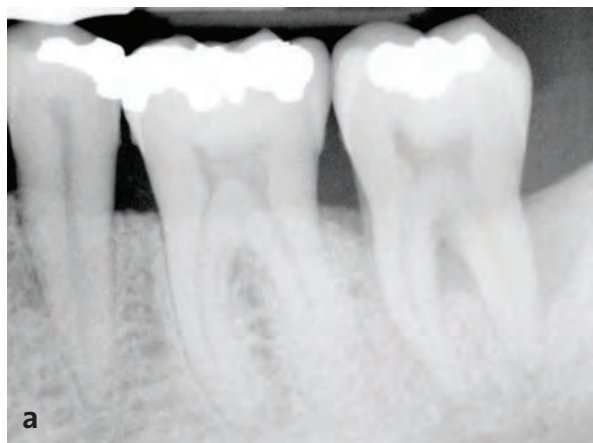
Preoperative clinical radiograph (a) and photo (b) of typical LANAP case.
